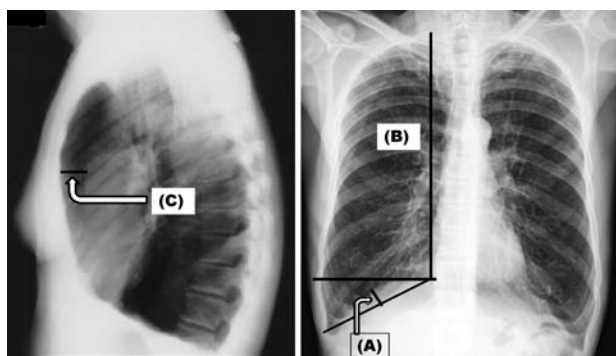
The measurements were made with an ordinary transparent ruler having 1mm increments. Different radiographic measurements were obtained as: (A) Right diaphragmatic height (DMHT) — measurements of a line perpendicular, from the top of dome of the right diaphragm, to a line joining the costophrenic and cardiophrenic angles; (B) Right lung length (LL) — distance from tubercle of 1st rib to the top of the dome of right diaphragm; (C) Retrosternal space (RSP) — horizontal distance from the posterior aspect of the sternum 3cm below the manubriosternal junction to the anterior margin of the aorta.
